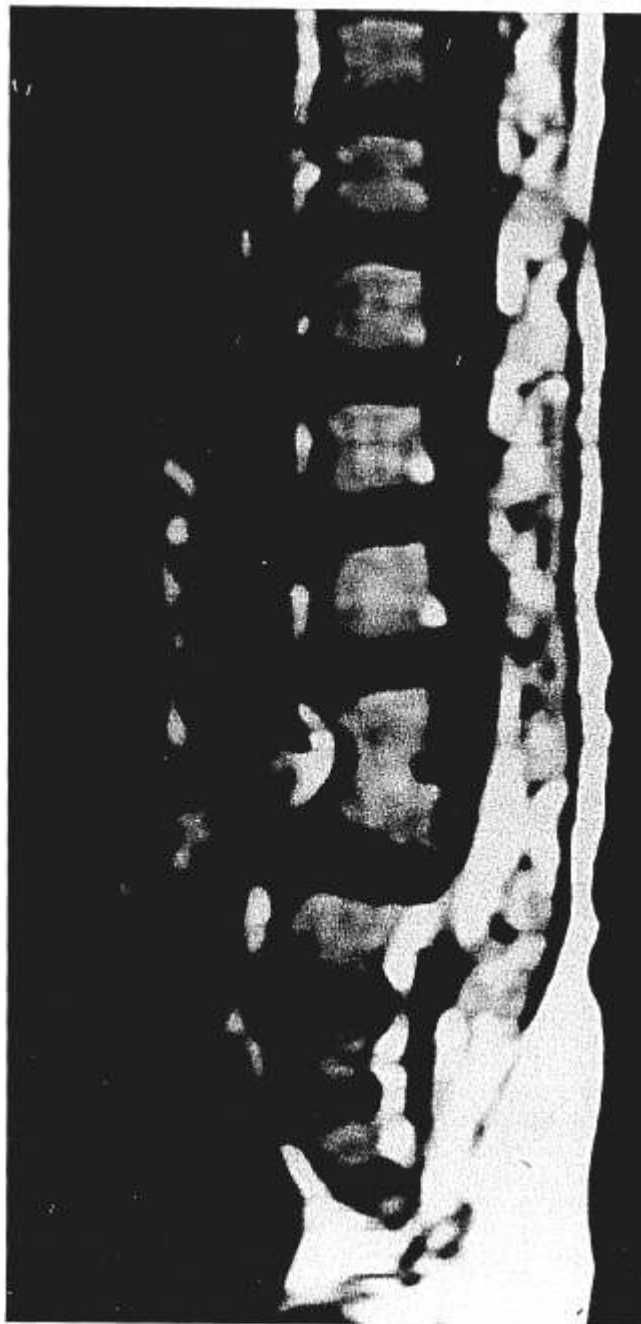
MRI of case 3. Sagittal section showing L4–L5 block vertebrae with kyphosis and lower sacral agenesis.
